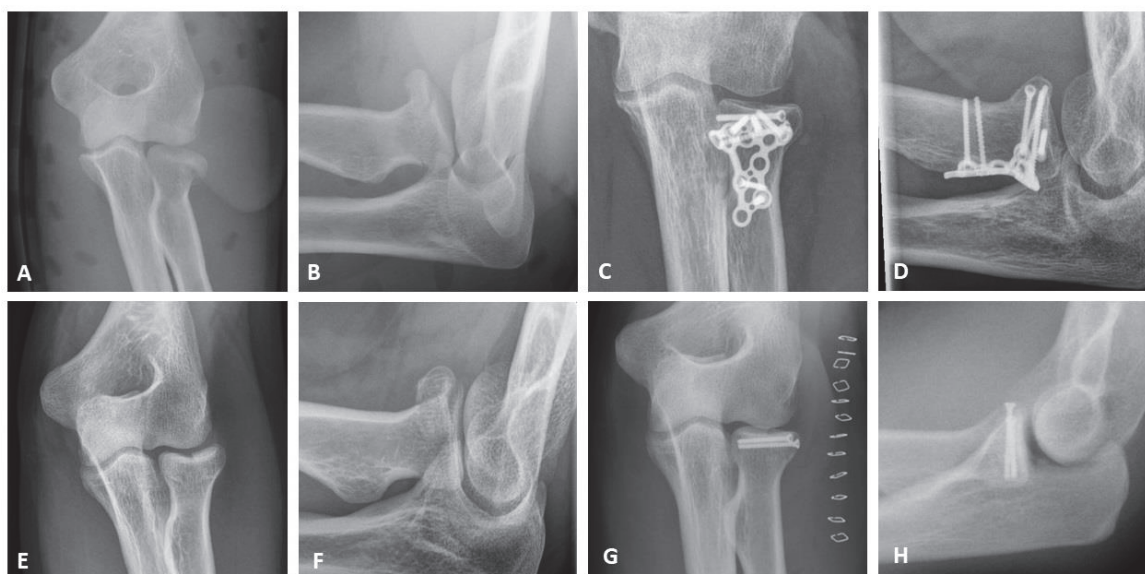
X-ray diagnostics; (A,B) Mason type II fracture in AP and lateral oblique view; (C,D) Mason type III fracture postoperatively after plate osteosynthesis in AP and lateral oblique view; (E,F) Mason type II fracture in AP and lateral oblique view; (G,H) Mason type II fracture postoperatively after screw osteosynthesis in AP and lateral view.
